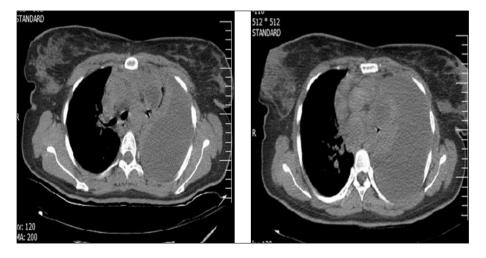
CT-scan of patient with massive pleural effusion and shift of mediastinum to right side during admission
